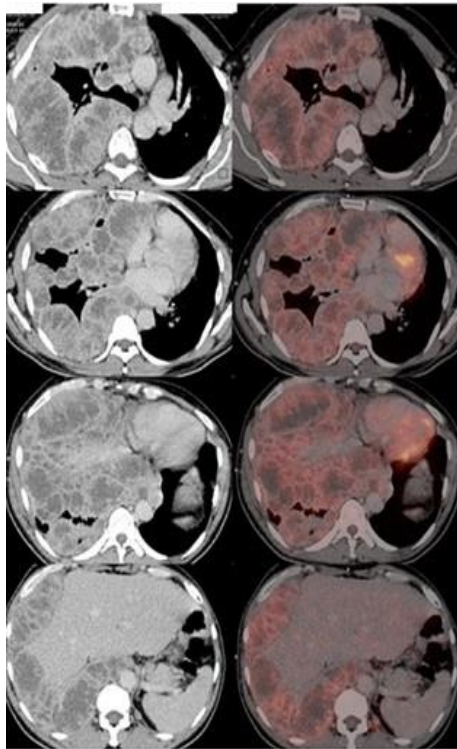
Multi-level axial CT and fused PET–CT of thorax — heterogeneous metabolic activity (SUVmax 8.9) with intensely FDG-avid mediastinal nodes (SUVmax 7.6).
